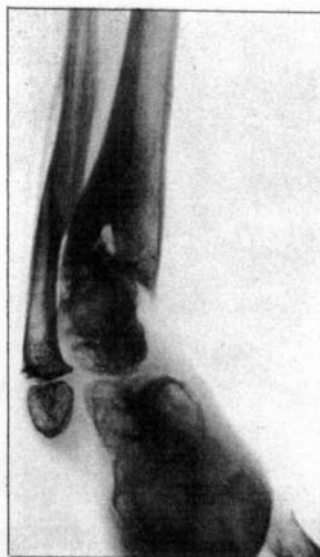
Case 3. Age six years and six months. Radiograph taken two months after correction of varus deformity by osteotomy of the right tibia and fibula.
